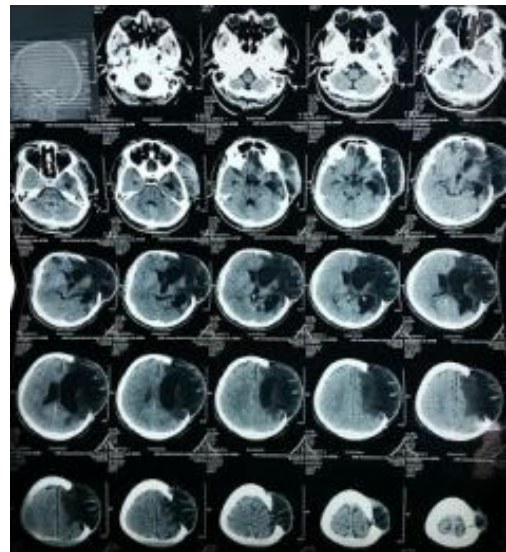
CT scan of same patient after 4 weeks interval showing hydrocephalus
